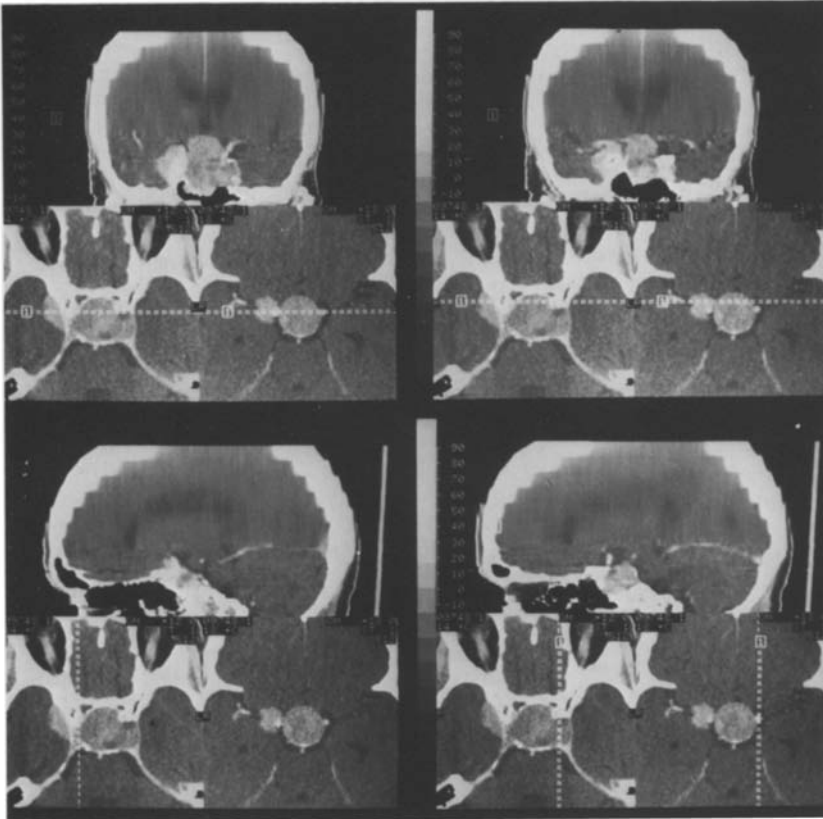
Pituitary adenoma with intrasellar and suprasellar extension and an enlarged sella. The right-sided parasellar meningioma can be differentiated on CT scan by localization and different contrast medium enhancement
